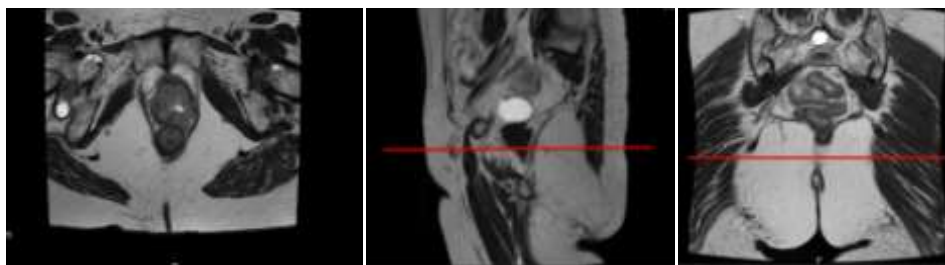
Magnetic resonance imaging (MRI) performed after induction chemotherapy.
